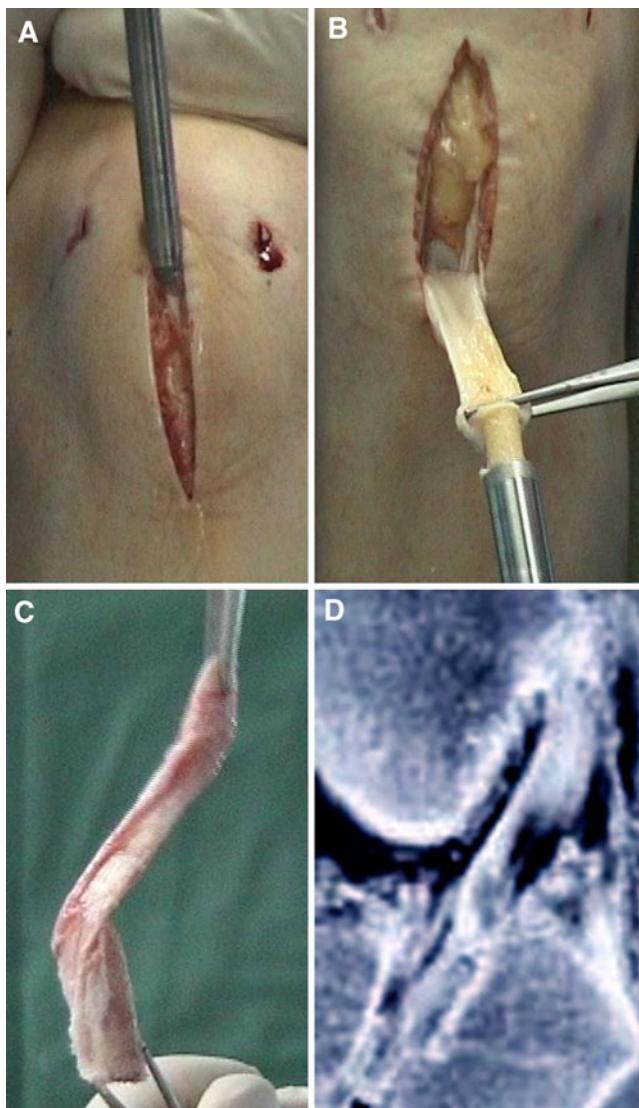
The 9-mm diamond instrument is grinding a bone cylinder out of the distal patella (a). The bone cylinder with the central third of the patellar tendon is pushed in the 11-mm diamond instrument to grind the 11-mm bone cylinder (b). The graft is harvested now with a 9-mm bone-tendon 11-mm bone. While rotating the distal BTB-transplant 90° to medial a different tensioning of parts of the tendon can be observed imitating the AM and PL bundle (c). An anatomic insertion can be observed in the MRI control (d)
